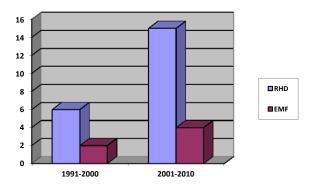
Number of publications in indexed journals that reported hospital or communitybased epidemiological and clinical studies using echocardiographic diagnosis for Rheumatic Heart Disease (RHD) and Endomyocardial Fibrosis (EMF) in the last two decades in Africa.
